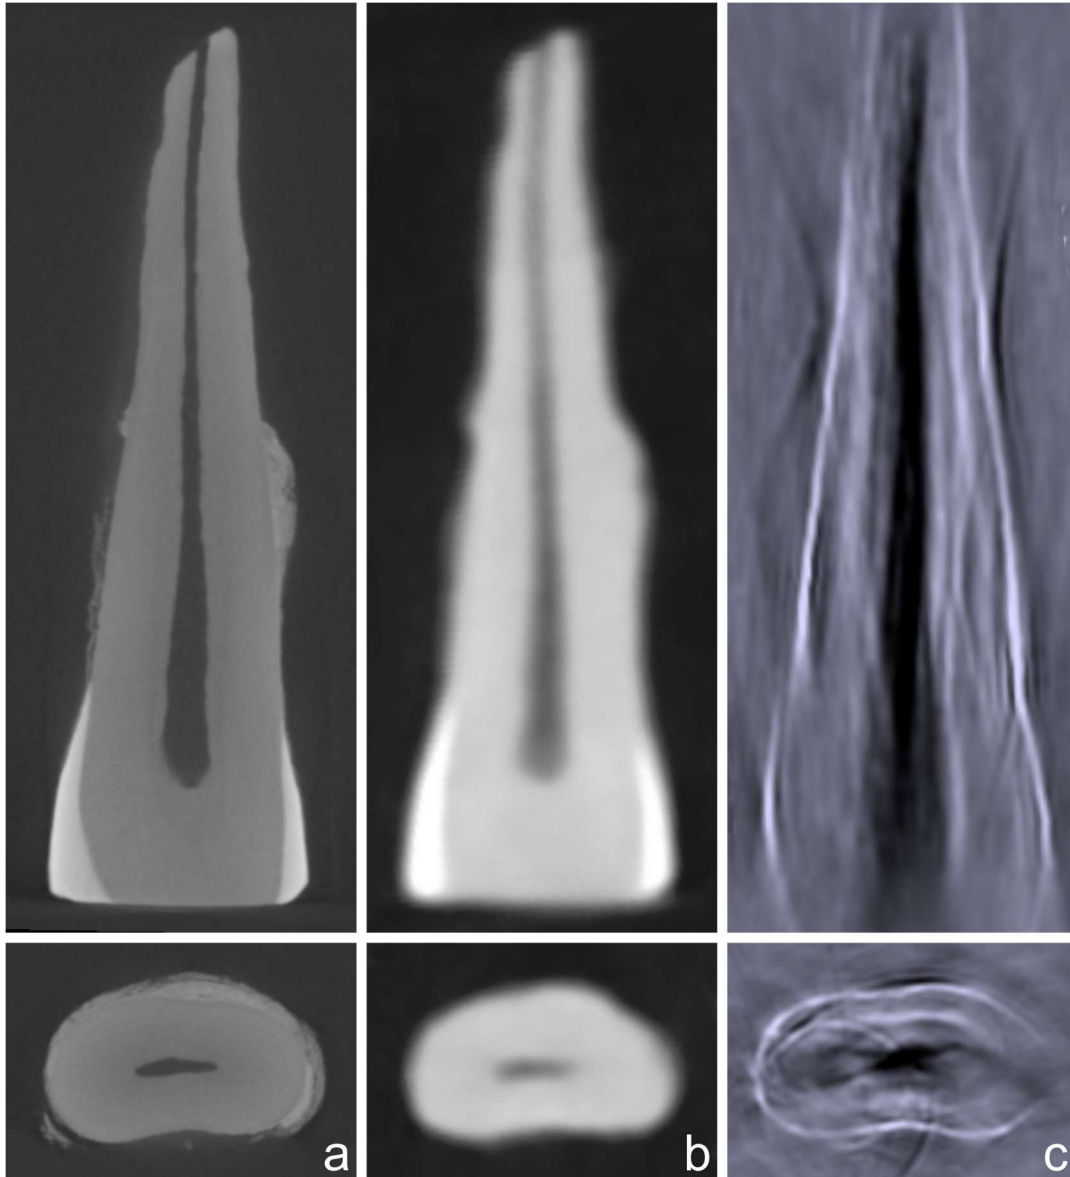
Comparison of μ -CT, CBCT, and PAT images. The images show the longitudinal and transverse section of human mandibular incisors. (a) μ -CT image, (b) CBCT image, (c) PAT image.
